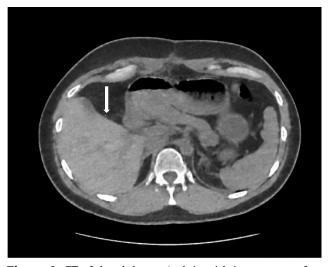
CT of the abdomen/pelvis with i.v contrast after radical cholecystectomy. White arrow indicates the postresectional liver surface.
